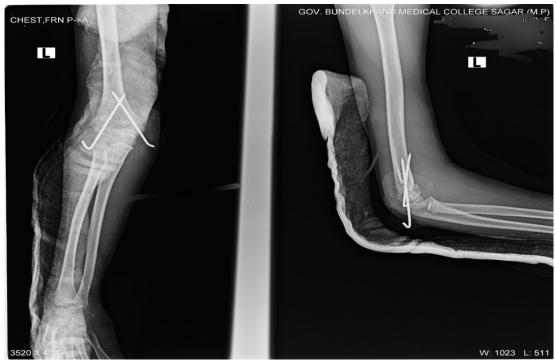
X-rays showing fixation with crossed pins
